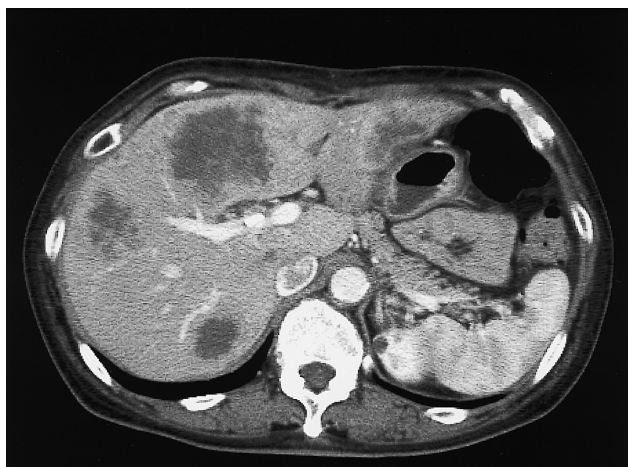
Contrast-enhanced CT image obtained after 3 HAIC cycles showing smaller liver metastases. The percentage of liver involvement with metastases improved from 42.8% to 33.9%.
